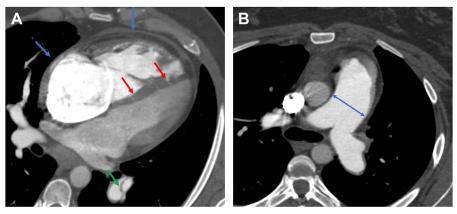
CT findings of pulmonary hypertension. (*A*) Four chamber reformation from CT pulmonary angiogram demonstrates enlargement of the right atrium and right ventricle (*blue arrows*) with flattening of the interventricular septum (*red arrows*). The right ventricle is hypertrophied. Note the band in the left lower lobe basal trunk in this patient with CTEPH (*green arrow*). (*B*) Enlargement of the main pulmonary artery relative to the ascending aorta.
